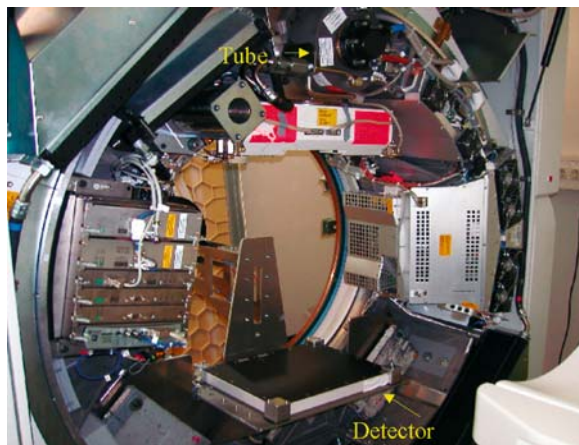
Prototype set-up incorporating a flat-panel detector into a standard CT gantry (SOMATOM Sensation 16)
